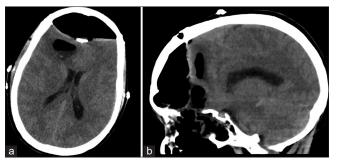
(a) Axial CT shows pneumocephalus with frontal lobe compression, (b) Sagittal view of the same scan.
